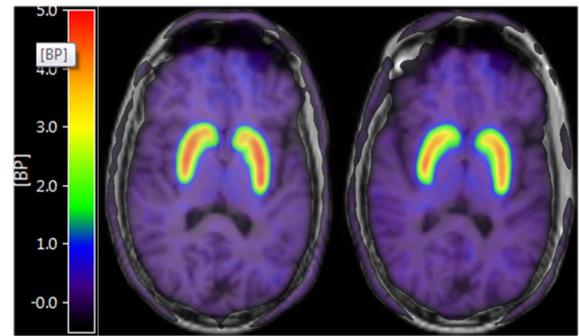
MRI anatomical image atop [¹¹C]raclopride pre-dose (left) and post-dose (right) BP_{ND} PET images for 1 subject
